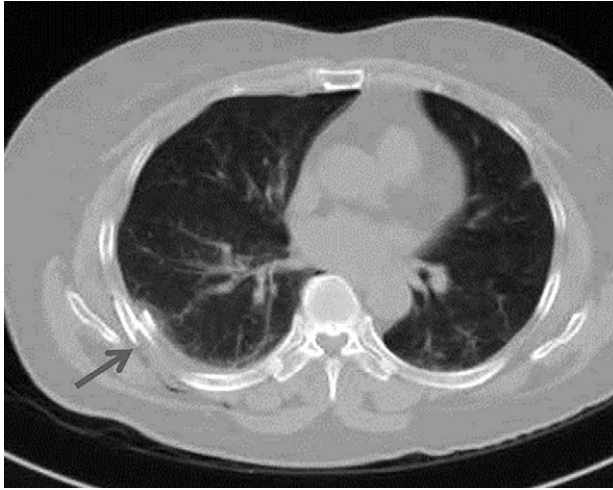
Chest computed tomographic scan showing multiple rib fractures (arrow), right minimal hemothorax, and right subcutaneous emphysema.
